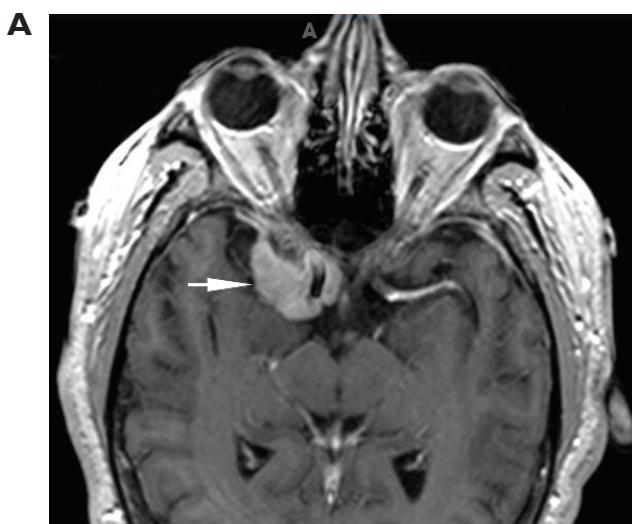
T1-weighted, axial MRIs after intravenous injection of paramagnetic contrast material in two cases of biopsy-proven sphenoid wing meningiomas. (A) Note similarity of enhancing lesion (arrowhead) that surrounds the right anterior clinoid process to the appearance of the lesion in Case 1. (B) Note similarity of enhancing lesion that involves the right orbit (small double arrowheads) as well as the medial sphenoid wing around the temporal lobe tip (large single arrowhead) to our Case 2.
